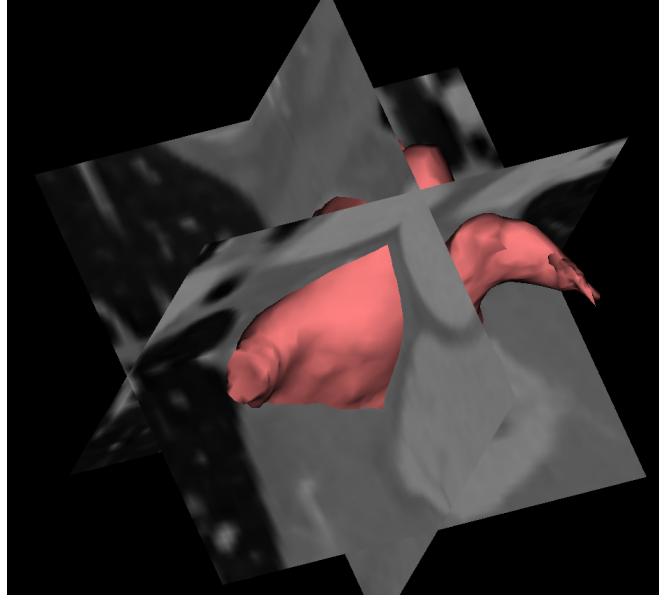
Preliminary result: a segmentation computed on a CT image of the atrial with a multi-atlas method based on SVF-Net.
